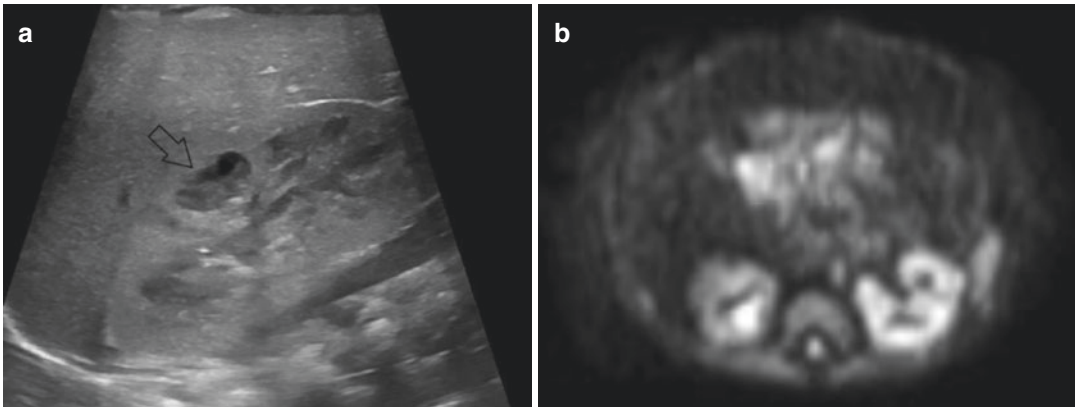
Case of Neonatal pyelonephritis with abscess. (a) US of the right kidney displacing a cortical abscess (arrow). (b) MR imaging, axial diffusion weighted sequence showing bilateral inflammatory involvement
